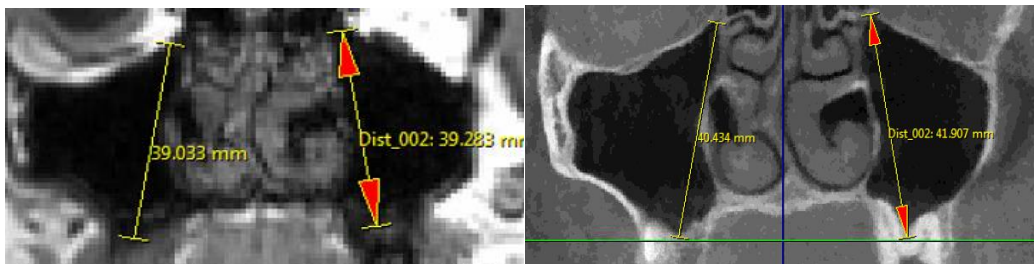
Measurement of the height of the maxillary sinuses. Shown here are right and left maxillary sinuses on CBCT slice (right) and MRI slice (left).
